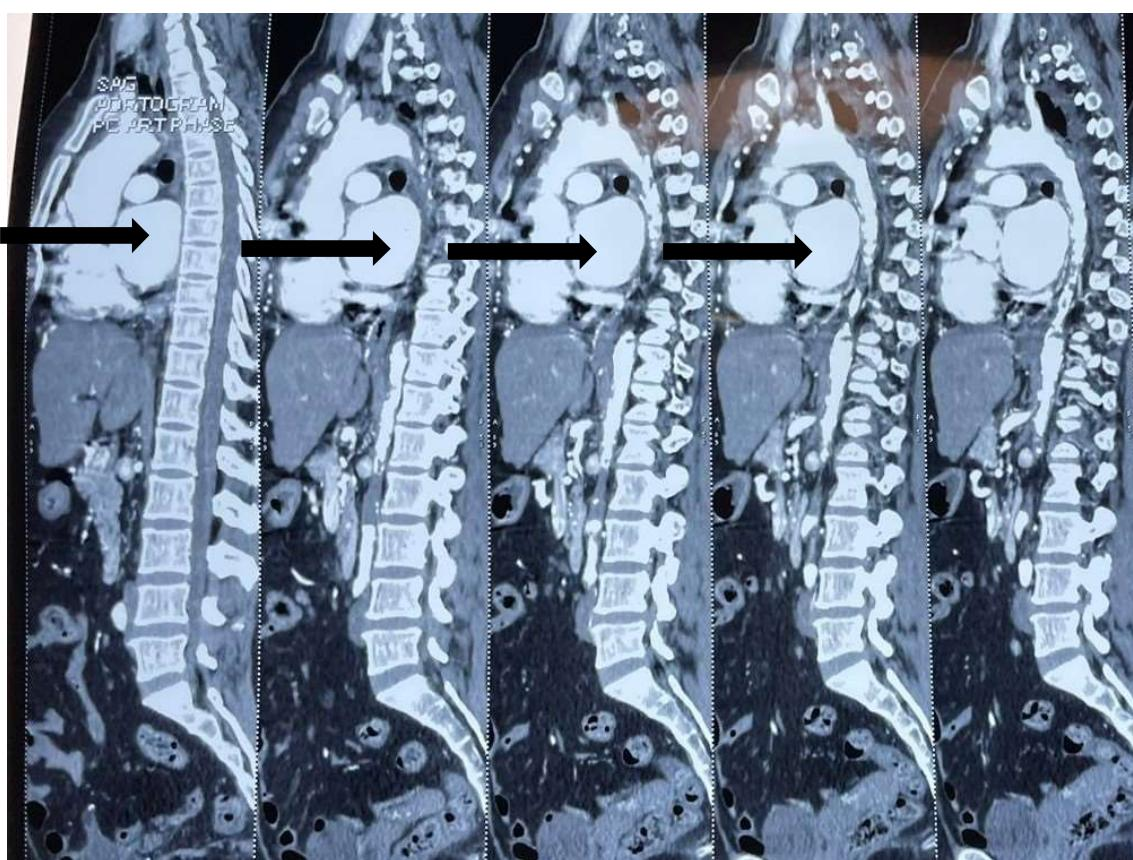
Preoperative sagittal section of CT aortogram showing aortic wall thickening from aortic arch to lower aorta
